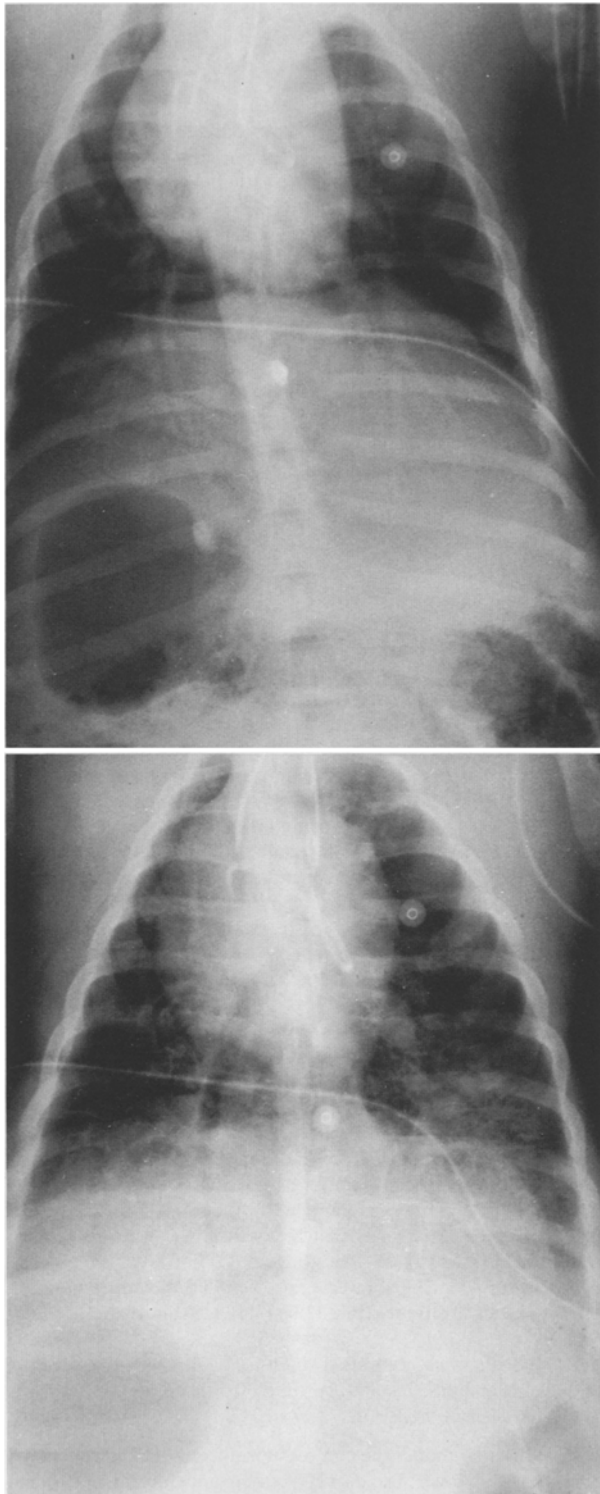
Chest X-rays before (top) and 5 h subsequent to lavage (bottom)
